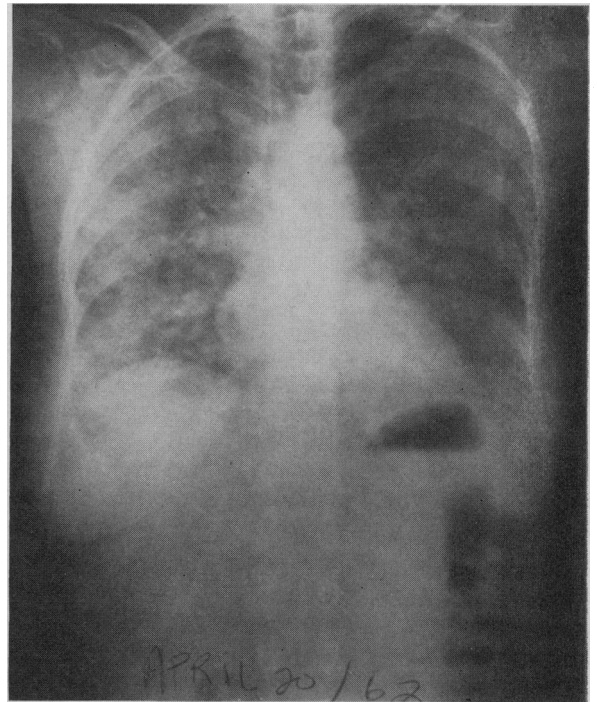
Case 3. Radiograph showing diffuse bilateral interstitial disease with some nodularity.
